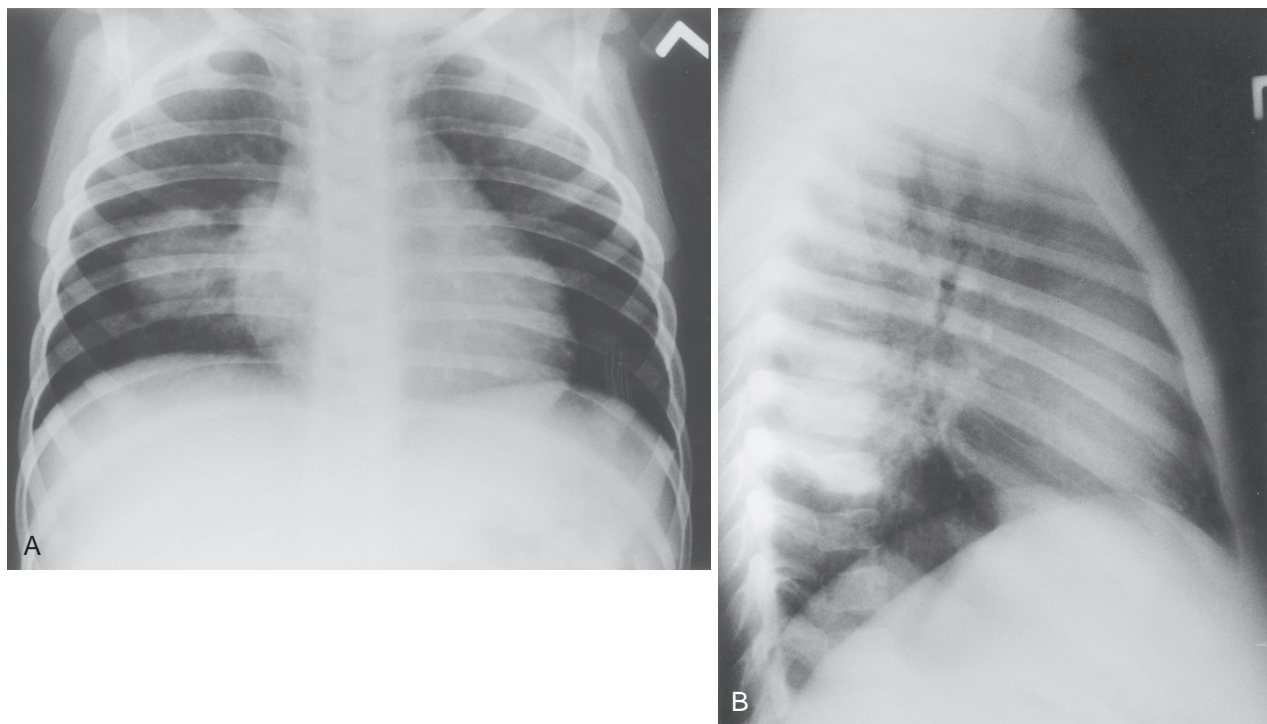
Chest radiograph of a 1.5-year-old boy with fever and dyspnea shows a typical round pneumonia of the superior segment of the lower lobe; an air bronchogram can be seen within the opacity. A, Anteroposterior view. B, Lateral view.
